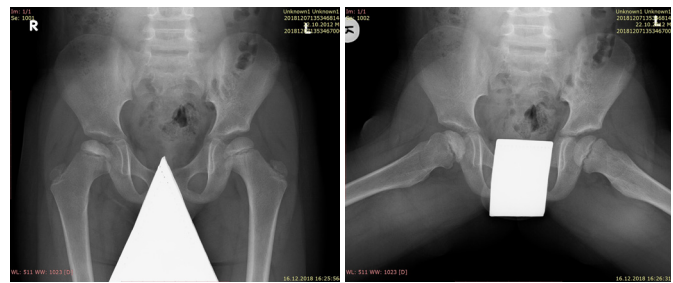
Radiographs of the pelvis in the anteroposterior (a) and Lauenstein (b) views: LCPD, right side, stage II.
